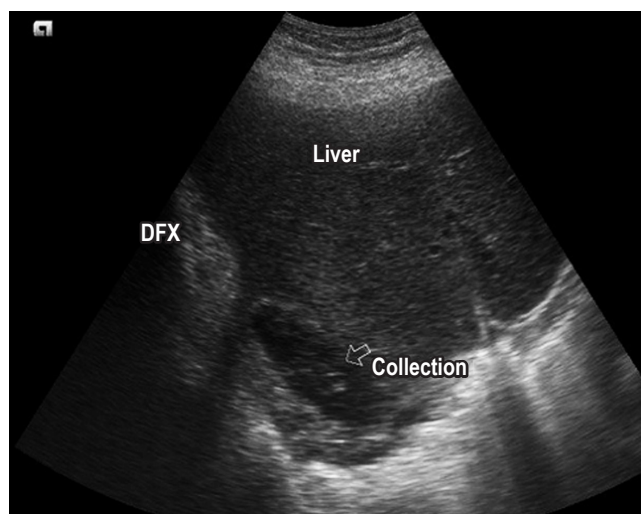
Abdominal ultrasound demonstrating sub phrenic fluid collection in a patient with history of dropped gallstones after laparoscopic cholecystectomy.
